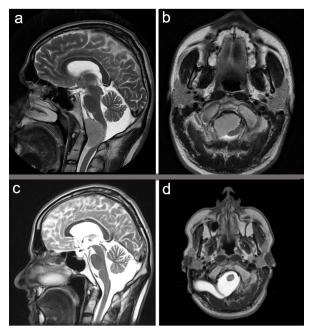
Foramen magnum meningioma tumor in a 25-yearold man visualized on MRI (T_2 sequence): sagittal section (a), transverse section (b), post-operative MRI (T_2 sequence) performed 2 years after surgery, demonstrating no lesion at the foramen magnum: sagittal section (c), transverse section (d)
